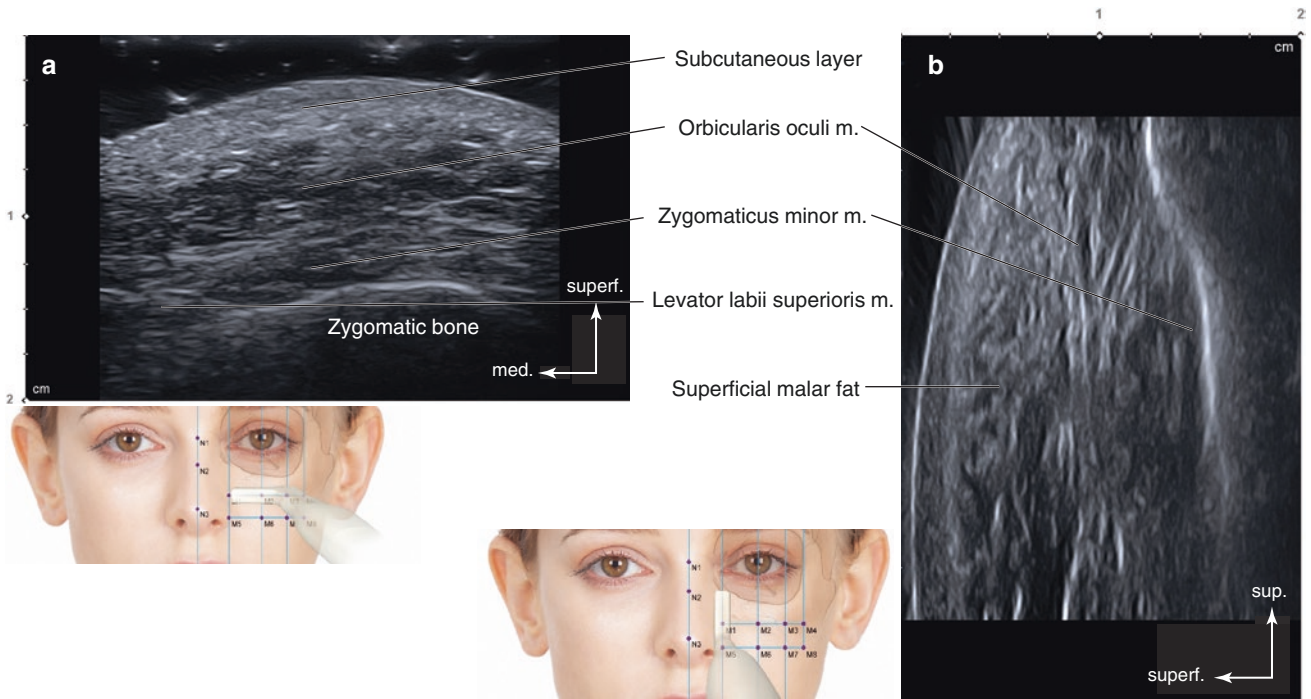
Ultrasonography on the intersection point of TL4 and PL3 (M3). (a) B mode (transverse view, 15 MHz by linear transducer) and (b) B mode (sagittal view, 15 MHz by linear transducer). (Published with kind permission of © Hee-Jin Kim 2020. All Rights Reserved)
